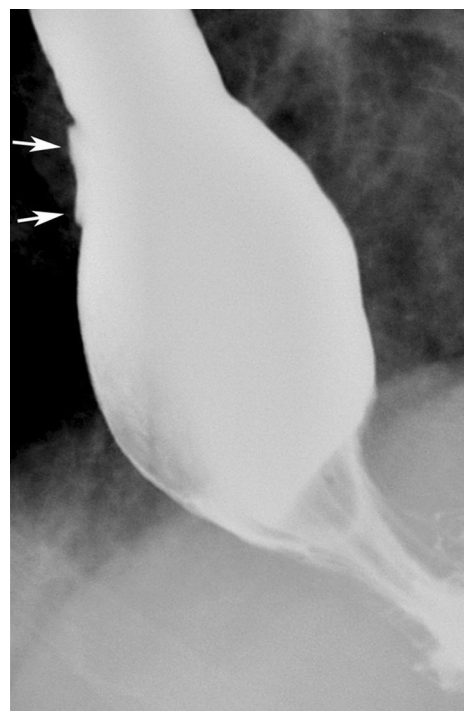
HIV esophagitis in HIV-positive patient. Upright, left posterior oblique spot image from double-contrast esophagram shows large, flat ulcer (arrows) in the distal esophagus abutting hiatal hernia. Endoscopic biopsies, brushings, and cultures were all negative for CMV, so this ulcer was thought to be caused directly by HIV. CMV and HIV ulcers are virtually impossible to differentiate on radiographic criteria, so endoscopy is required for a definitive diagnosis.
